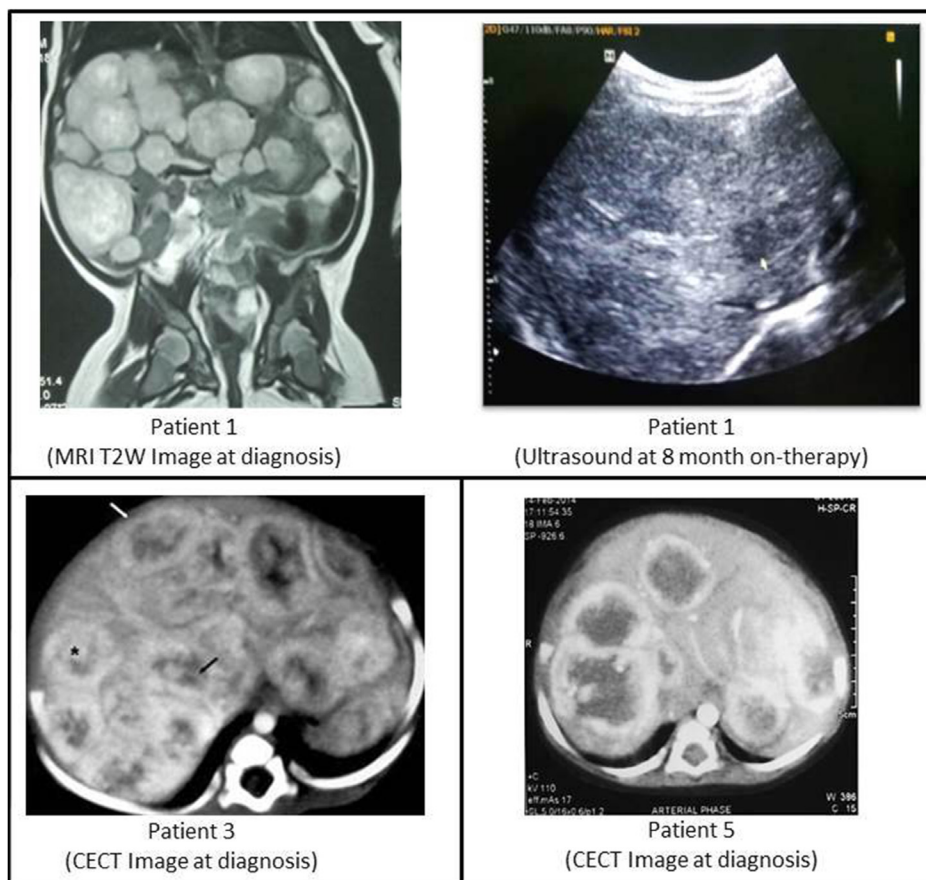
Selected representative images of IHH lesions from the reported patients. MRI, magnetic resonance imaging; CECT, contrast enhanced computed tomography.
